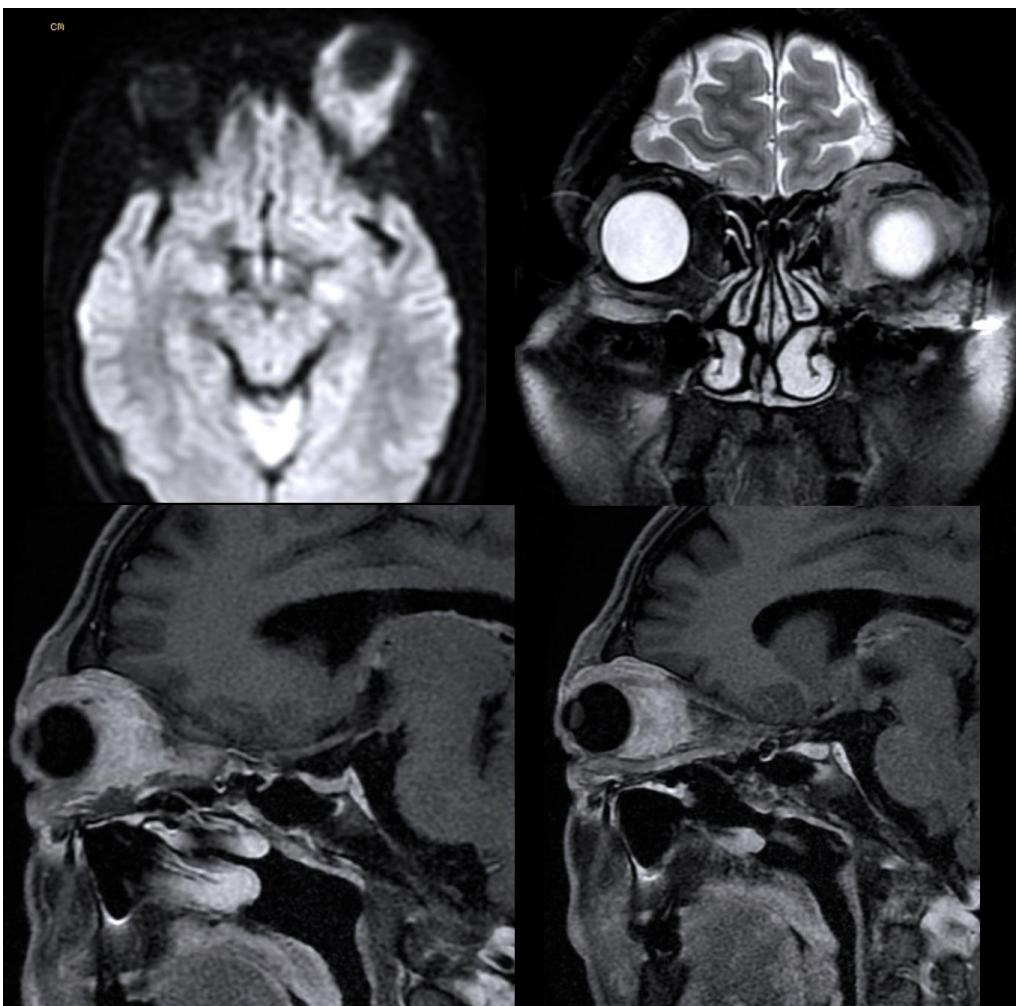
Laki2, 40 th dengan mata merah, nyeri kepala dan ganguan penglihatan mata kiri, pada CT Scan kepala tanpa dan dengan kontras tampak multiple lesi di post septal orbita kiri, daerah muscle cone, intraconal hingga sinus cavernosus kiri, epidural space temporal kiri, dan intraaxial, MRI menunjukkan gambar yang lebih jelas berupa selulitis orbita di post septal intraconal, muscle cone orbital fat thrombosis sinus cavernosus kiri, epidural empyema temporal kiri dan intraaxial abscess di temporal kiri dengan penyebab sinusitis sphenoidalitis kiri. Abscess menunjukkan *restricted diffusion* di DWI (Sri Andreani Utomo).
